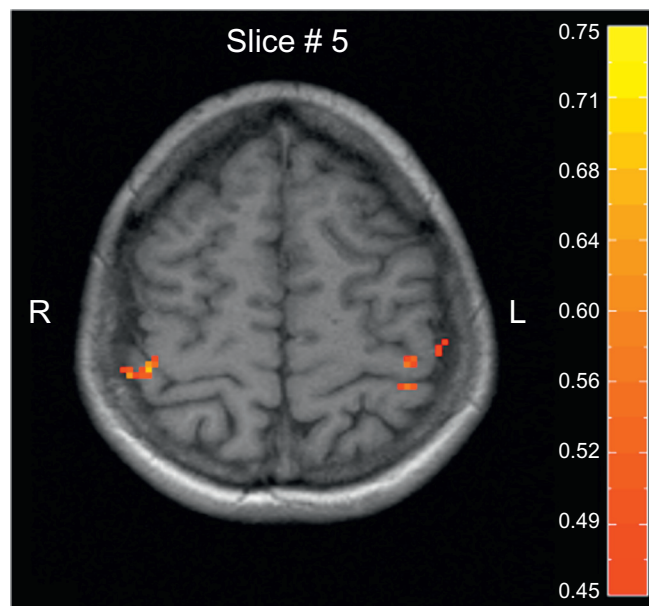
Functional MRI results in a patient (19-year-old right-handed woman) with left hemianesthesia due to conversion hysteria (normal MRI of the brain and spine, and normal sensory and motor evoked potentials), following a minor car accident (Vuilleumier and Assal, unpublished data). Activation during blocks of bilateral tactile stimulation showed bilateral increases in somatosensory cortex, but stronger in the contralateral than ipsilateral hemisphere.
